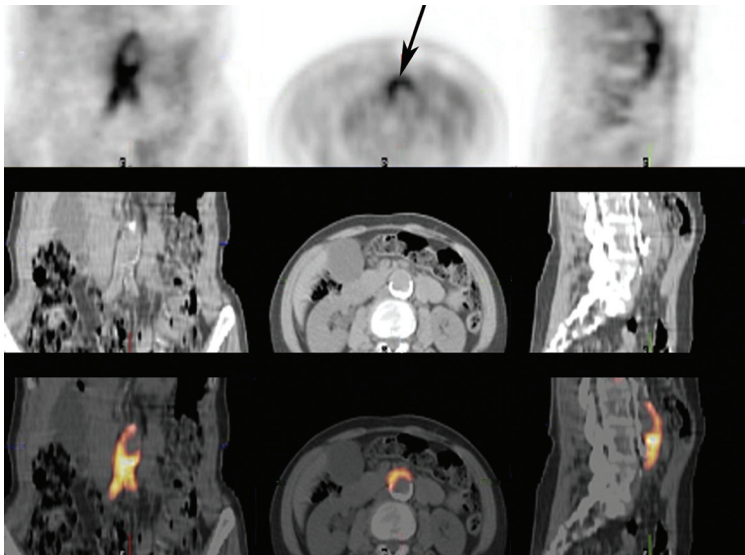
Fusion of FDG-PET and CT data. The top row shows FDG-PET data in the coronal, transverse, and sagittal planes (left to right). The middle row depicts the corresponding location on CT. Fusion of both datasets provides detailed anatomical and functional information (bottom row). On the axial images, FDG uptake is located within the anterior aneurysm wall. No FDG uptake is observed in the heavily calcified posterior aneurysm wall.
